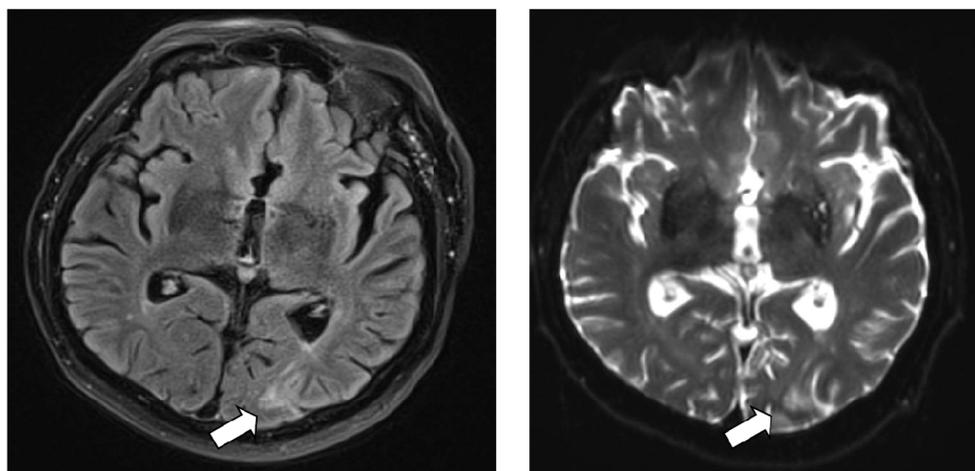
White arrow showed infarct lesion in the left occipital lobe during MRI.
